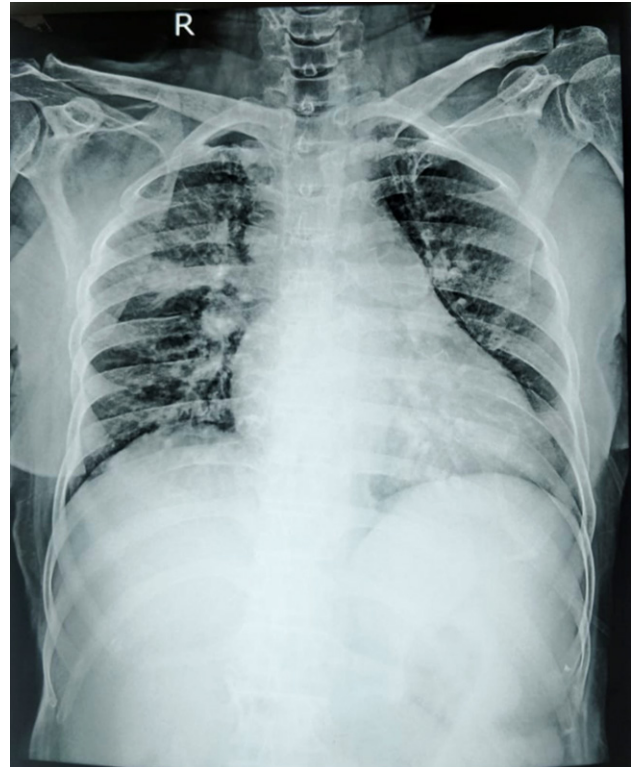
X-ray chest- Consolidation in right middle lobe of lung with lymphadenopathy
